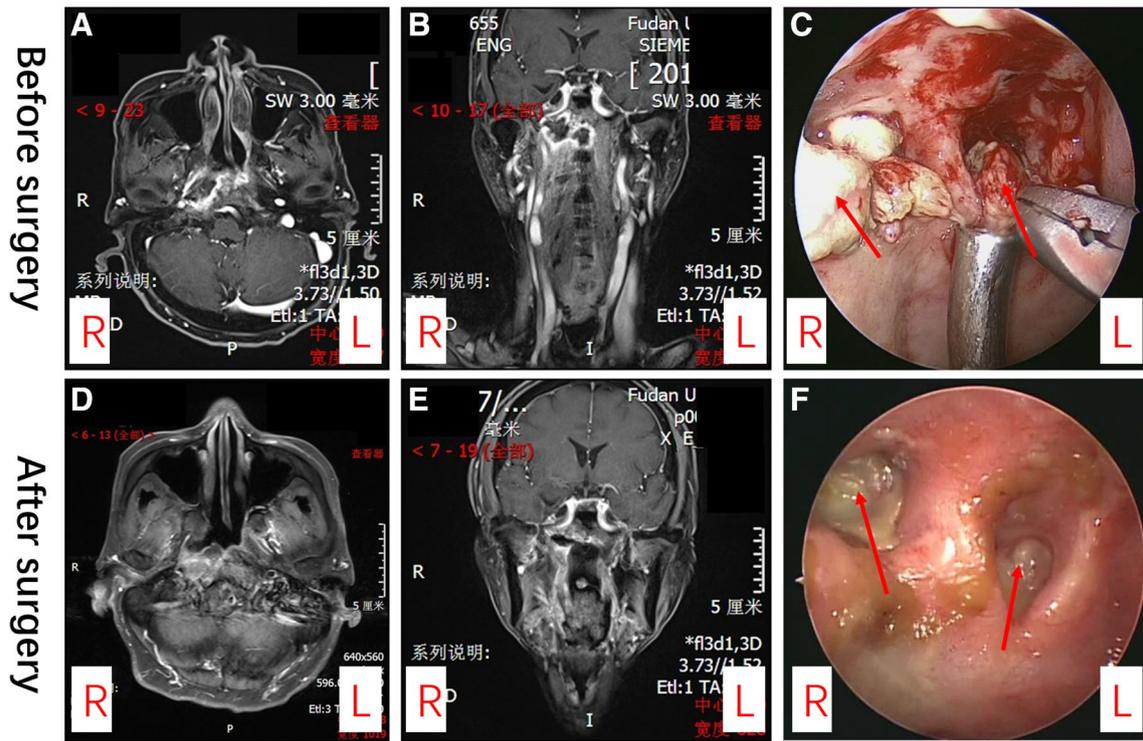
a, b The preoperative image examinations (MRI) of the first representative case. c The necrotic tissues in the surgery. d, e The postoperative image examinations (MRI) at the 6-month follow-up. f The epithelization of the wound
